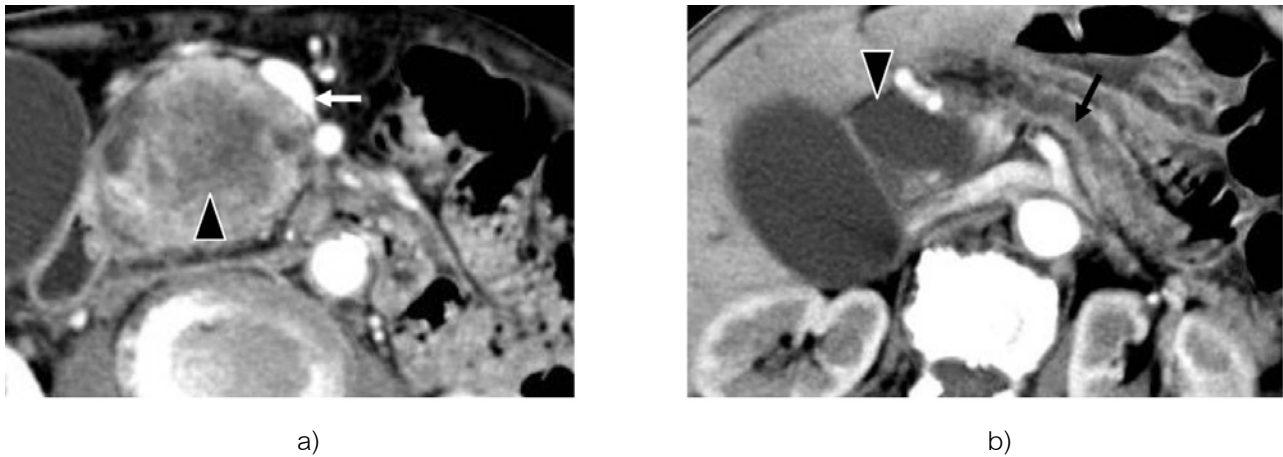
CT scan on arterial phase of a 68-year-old patient with a hypodense mass at the pancreatic head and uncinate process (poorly-differentiated adenocarcinoma) seen as in : (a) (arrowhead) with tear-drop configuration of SMV (white arrow) representing SMV involvement; (b) the mass causes dilatation of CBD (arrowhead) and pancreatic duct (arrowed) or double duct sign.
